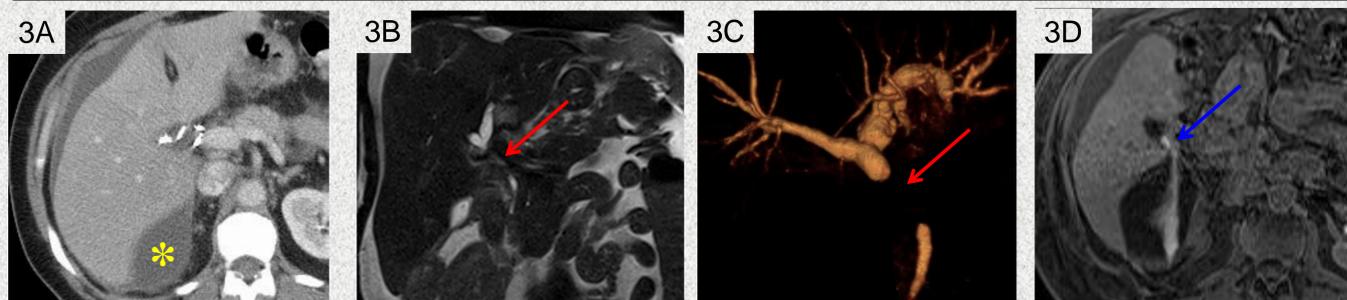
(A) CT, (B) Coronal T2-W MRI, (C) 3D-MRCP, (D) postcontrast MRI with gadopetate disodium in the hepatocyte phase. Perihepatic fluid collection (3A,*) which is nonspecific in etiology on CT. This was confirmed to represent biloma on MRI as evidenced by extravasated contrast material (3D, blue arrow) on hepatocyte phase images. There is segmental non-visualization of the common duct (3B-C, red arrows).
